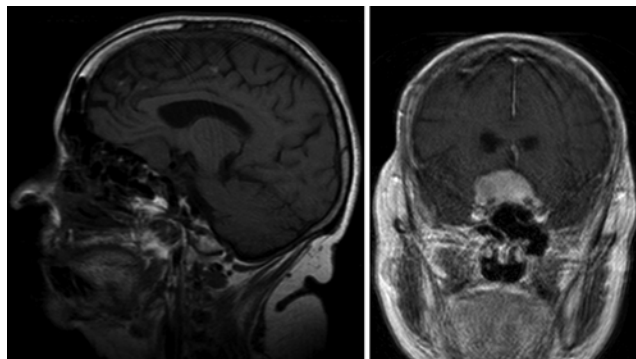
Case 1. Sagittal T1-weighted MR imaging without contrast enhancement (left) and coronal T1-weighted MR imaging with contrast enhancement (right) showing a tuberculum sella extraaxial lesion consistent with meningioma. The lesion measured 2.5 × 1.7 cm. No treatment was offered, and the tumor has been monitored for more than 5 years with no changes in size or symptoms.
